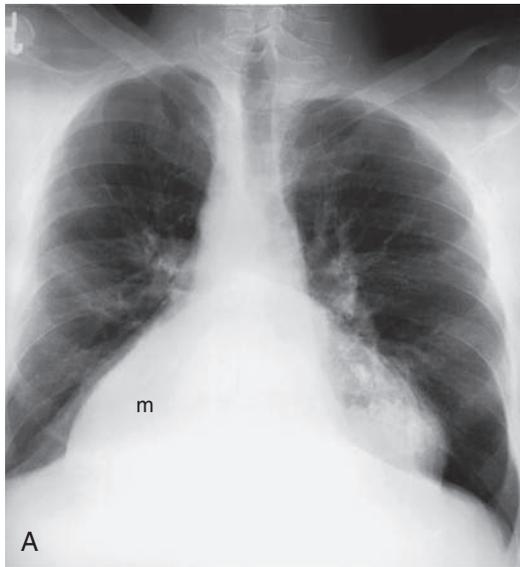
Posterior mediastinal mass. A, Posteroanterior chest film shows a large soft tissue density (*m*) obscuring the right heart border and the right hemidiaphragm. B, Computed tomography image at this level shows a large retrocardiac diaphragmatic hernia containing omentum and stomach.
